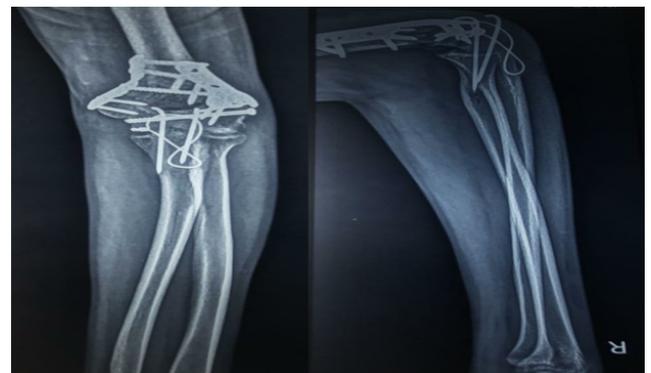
Follow-up radiograph at 3 months
